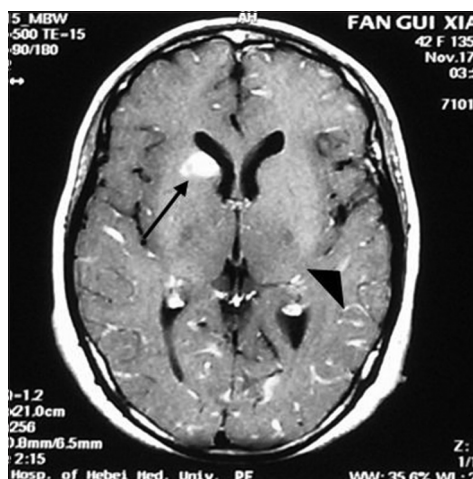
Brain magnetic resonance imaging scan presented multiple high-signal lesions on T2-weighted and fluid attenuated inversion recovery. Remarkable intensity of leptomeninges and abnormal strengthening in the right side of the caudate nucleus
